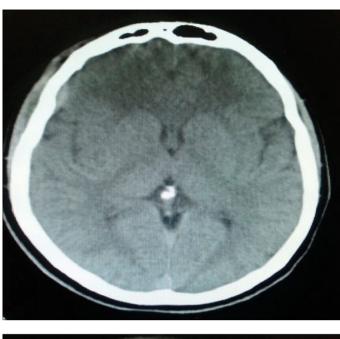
a, b. Computed tomography image at the admission (a), computed tomography image at the 8^{th} hour of admission (b)
